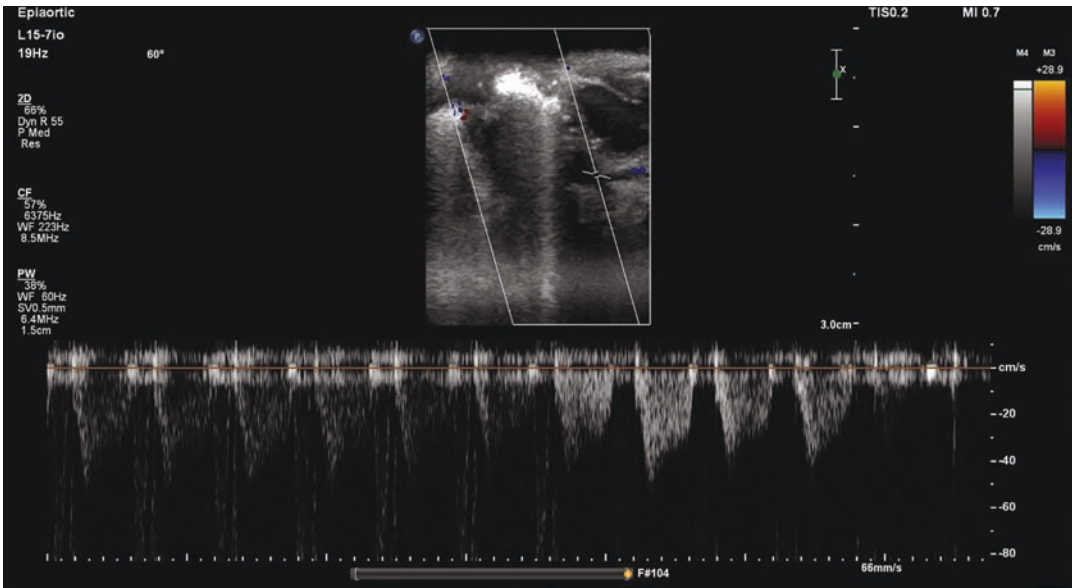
Postoperative Doppler interrogation of coronary flow after ALCAPA repair using the high-frequency “hockey-stick” probe. The flow pattern is relatively normal with an acceptable peak velocity measuring ~40 cm/s
